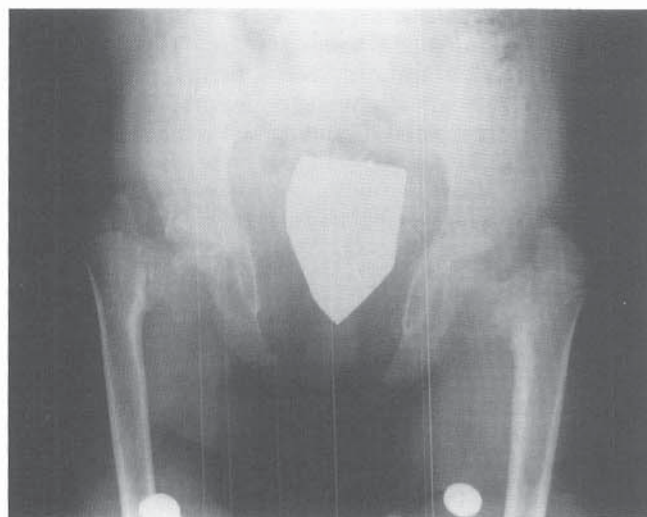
Pelvic radiograph of a 9-year-old child with cleidocranial dysostosis. The symphysis pubis is wide, and coxa vara is present bilaterally.
